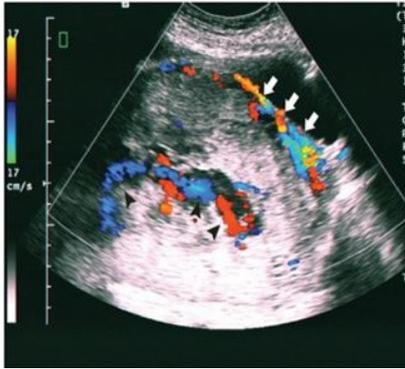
The B-ultrasound showed that the placenta was located in the anterior wall and completely cover the uterine neck, the placental blood vessels invade myometrium and the boundary of the bladder were not clear.
